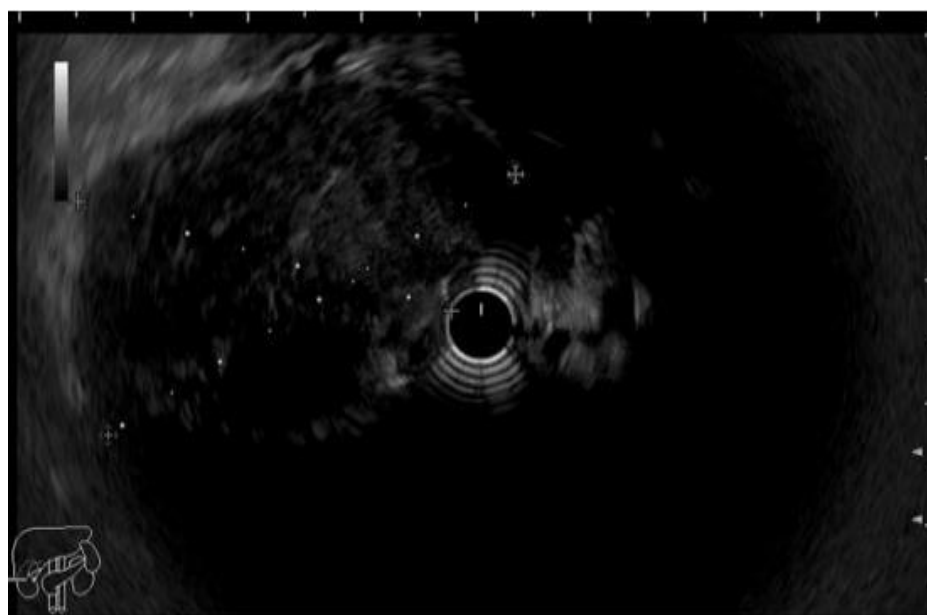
Endoscopic ultrasound image of a heterogeneous, large, well-limited solid mass consistent with gastric GIST
